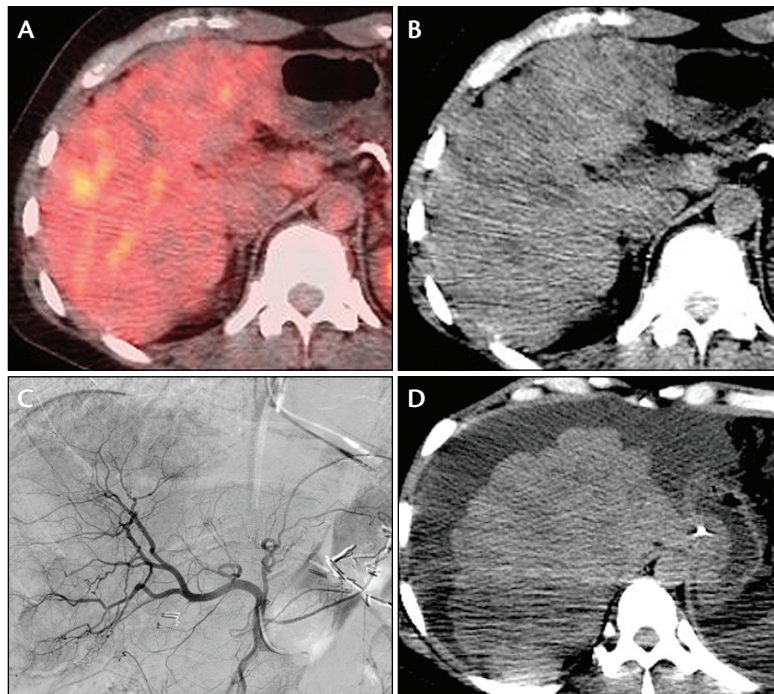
Fused PET/CT (A) and CT (B) images demonstrated multiple PET-avid liver metastases in the background of nodular liver due to pseudocirrhosis. The angiogram showed multiple large hypervascular masses in the right liver lobe (C). Follow-up CT obtained 3 weeks after TACE demonstrated new-onset ascites (D).
